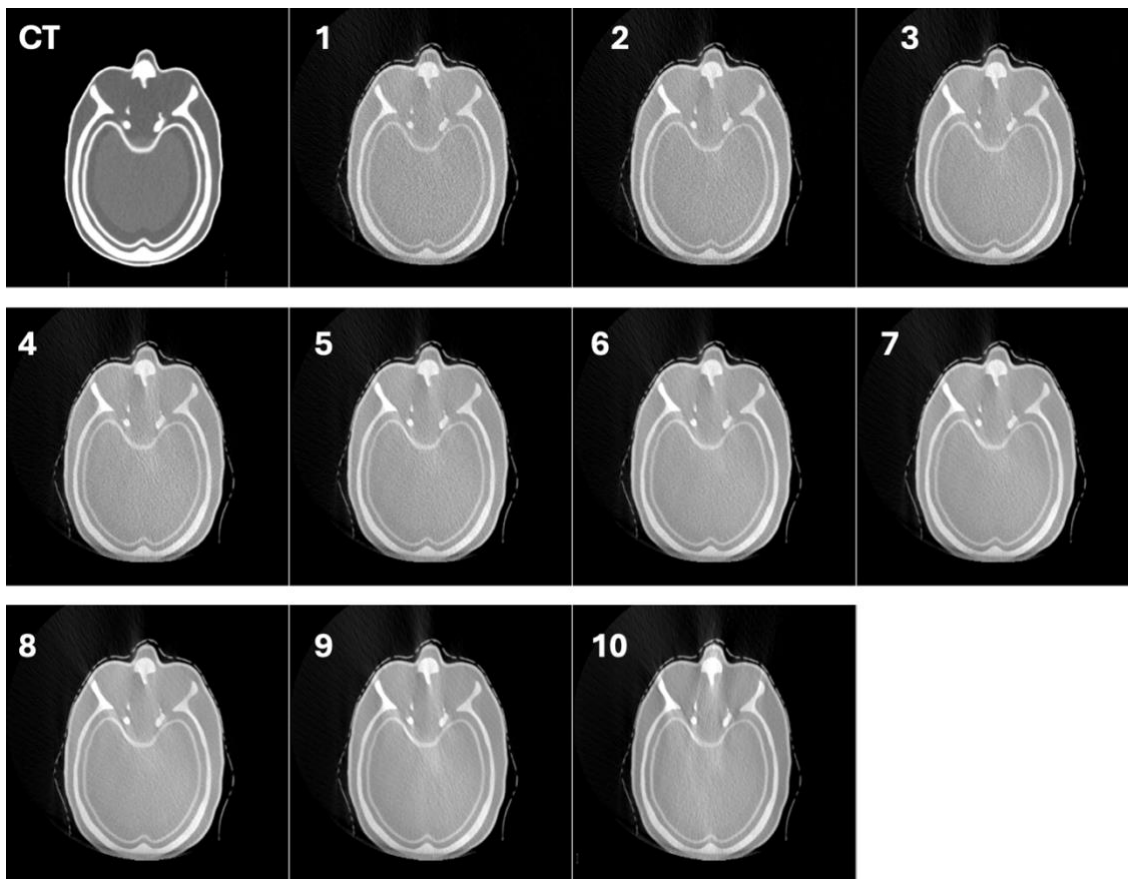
Axial CT image and axial CBCT images from 10 different CBCT protocols at the same level. The first image on the top left is a conventional axial CT scan, followed by axial CBCT images labeled 1 to 10, showing variations in image quality.
